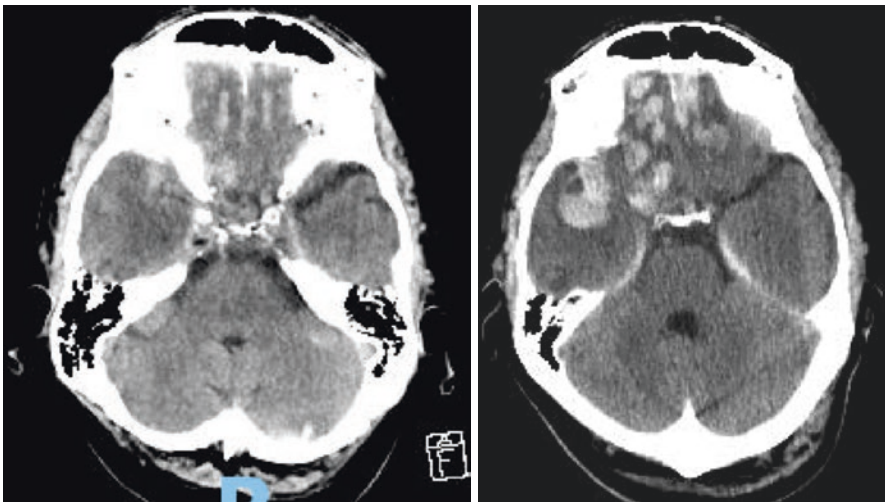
CT head demonstrating bifrontal and a right temporal contusion (left) with blossoming of the contusions on a scan obtained 6 hours later (right)
